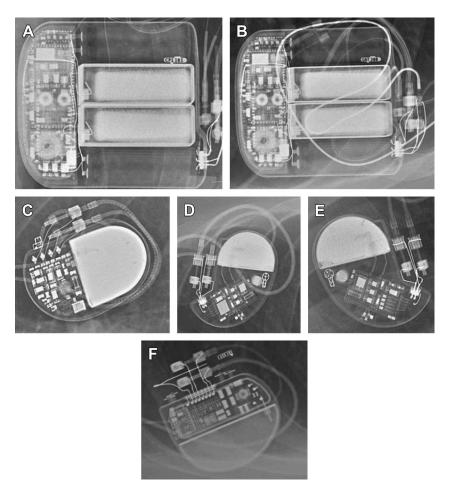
Radiographic identifiers for some generator manufacturers. PM and ICD generators can be identified from operative dictations, patient cards, or some chest radiographs. Using digital radiograph equipment with postprocessing zoom capability, corporate radiograph logo identifiers from CPI (*A*), Guidant (*B*), Medtronic (*C*), Pacesetter (*D*), St Jude Medical (*E*), and Boston Scientific (*F*) are shown. (*From* Rozner MA. Implantable cardiac pulse generators: pacemakers and cardioverter-defibrillators. In: Miller RD, Eriksson LI, Fleisher LA, et al, eds. Miller's Anesthesia, 7th edition. Philadelphia: Elsevier, 2009; with permission.)
